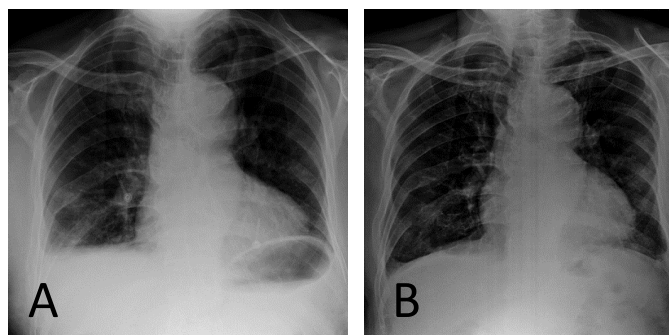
Chest radiographs on admission and upon discharge. Pneumonic infiltrates in the right paracardiac area and right-sided pleural effusion were noted during admission (A). There was regression of findings in the discharge chest X-ray (B).
